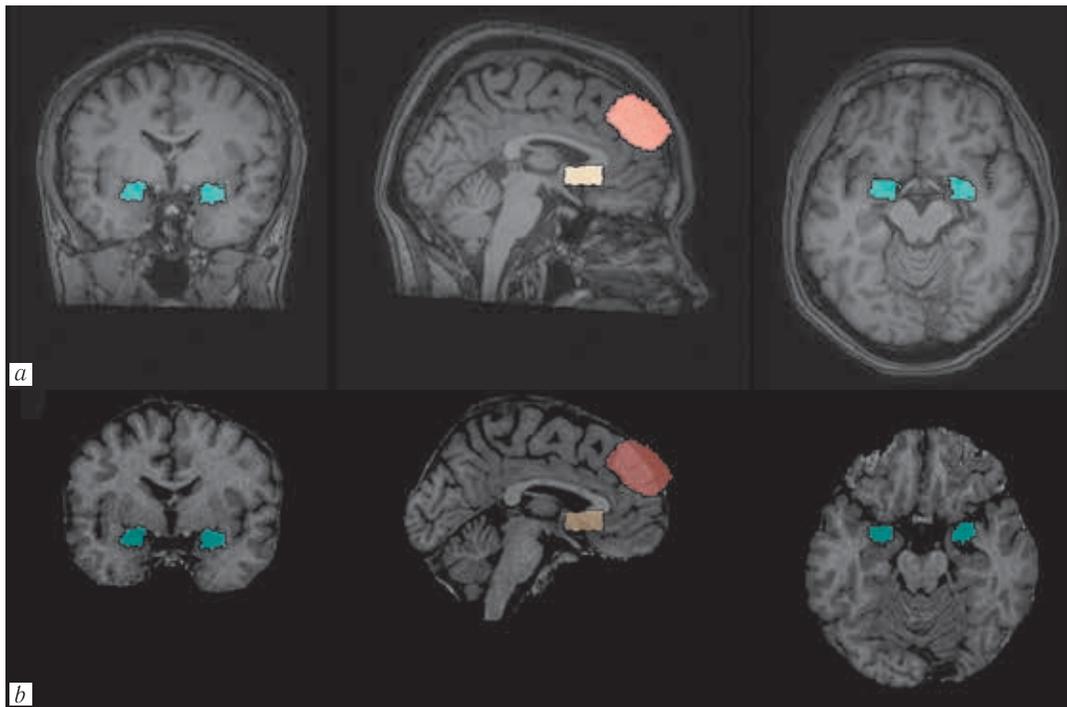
Representation of the three ROI examined in this article obtained from one of MDD patients (37 y.o. female). Blue: bilateral amygdala; red: dorsomedial prefrontal cortex (dmPFC); yellow: anterior cingulate cortex (ACC) placed on the three-dimensional sample source images: (a) T1-weighted image and (b) macromolecular proton fraction (MPF) map
